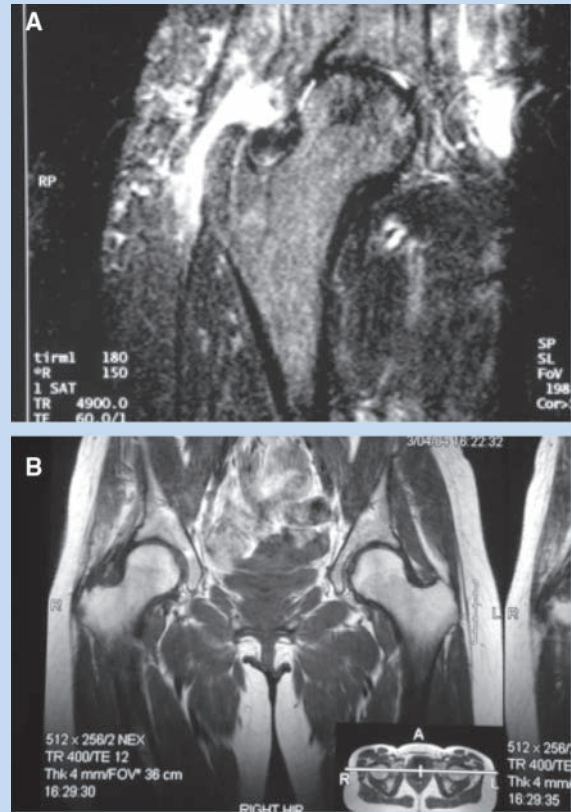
A, T2 MRI of the right hip demonstrating an avulsion of gluteus medius and gluteus minimus tendons; B, T1 MRI of the pelvis 2 years after open repair of the gluteus medius and minimus tendons.
